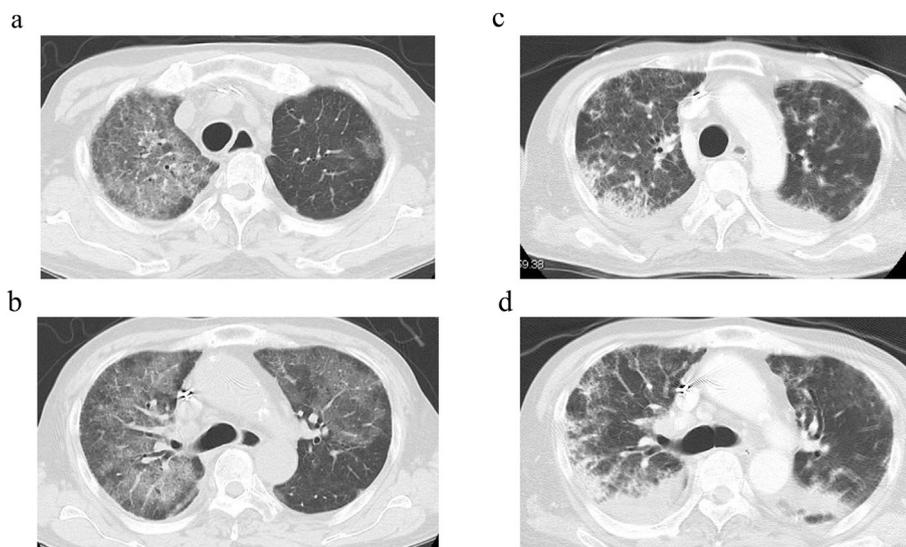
Representative chest Computed Tomography findings. a, b) Chest CT shows diffuse ground glass opacities and septal thickening and traction bronchiectasis on the admission day. c, d) Chest CT on shows bilateral exacerbation of consolidation and traction-bronchiectasis the 22nd hospital day.
